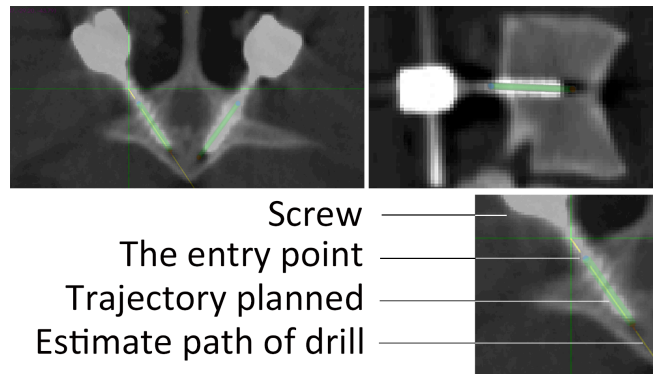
Screw position accuracy measurements on post-operation CT scan by merging methods.
